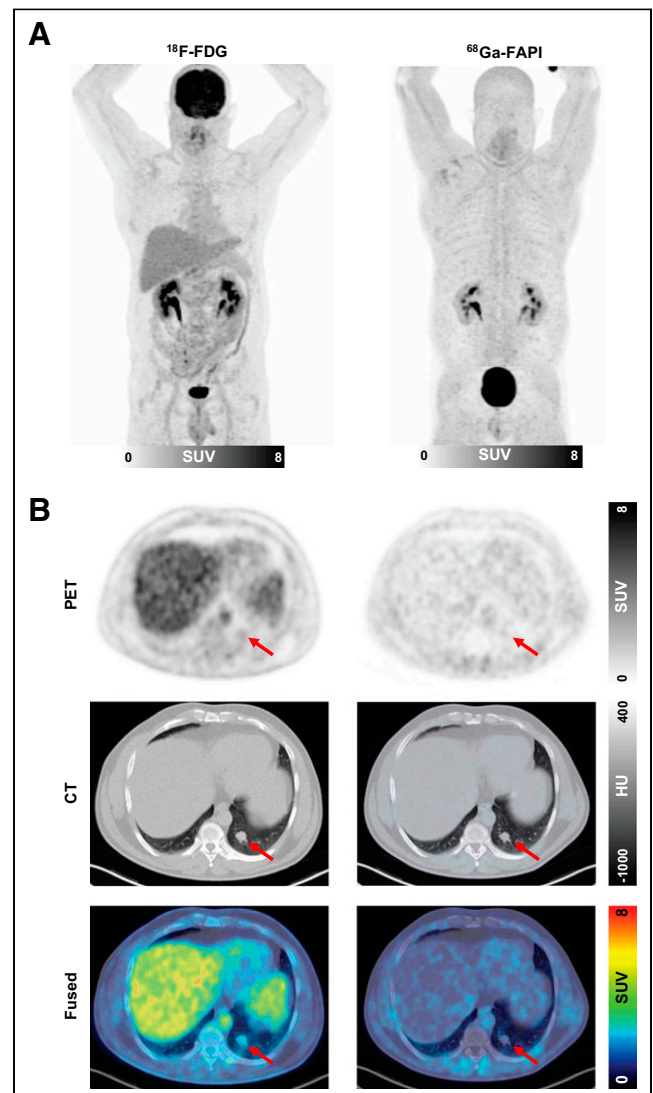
Example ^{18}F -FDG and ^{68}Ga -FAPI-46 images of 41-y-old man with hamartoma in left lower lobe. (A) Maximum-intensity-projection PET images. (B) Axial images of suggestive lesion (arrows) in left lower lobe. After wedge resection, hamartoma was diagnosed by pathology. HU = Hounsfield units.
